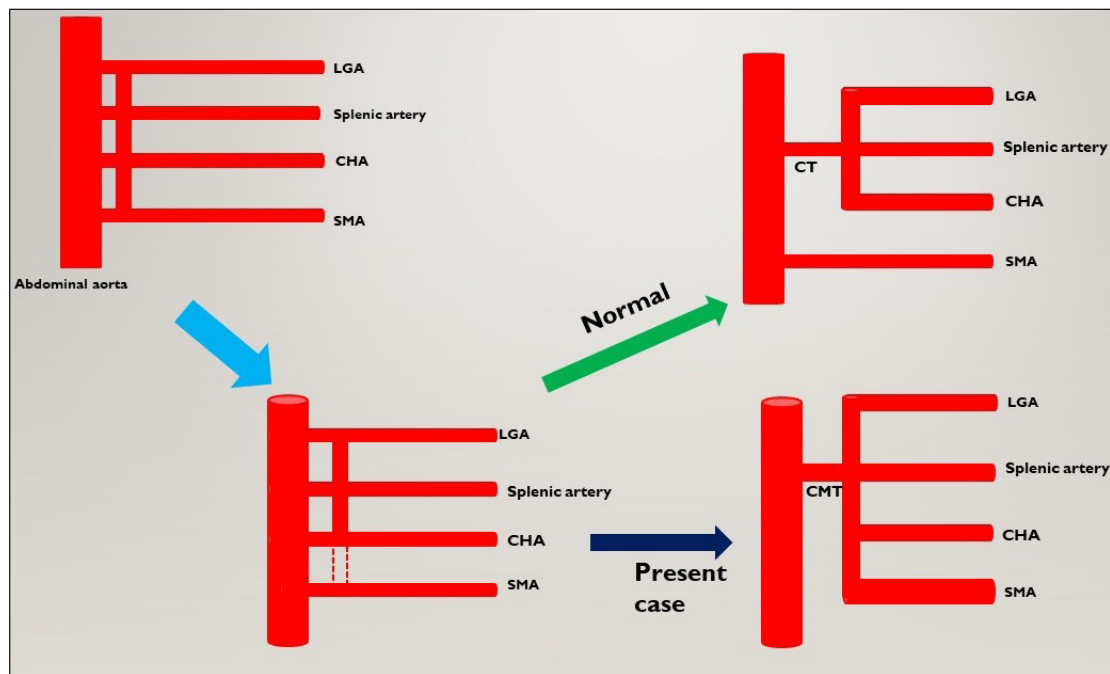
Depicting short-type coeliacomesenteric trunk. CT: Coeliac trunk, LGA: Left gastric artery, CHA: Common hepatic artery, SMA: Superior mesenteric artery, GDA: Gastroduodenal artery, HAP: Hepatic artery proper, CMT: celiacomesenteric trunk
